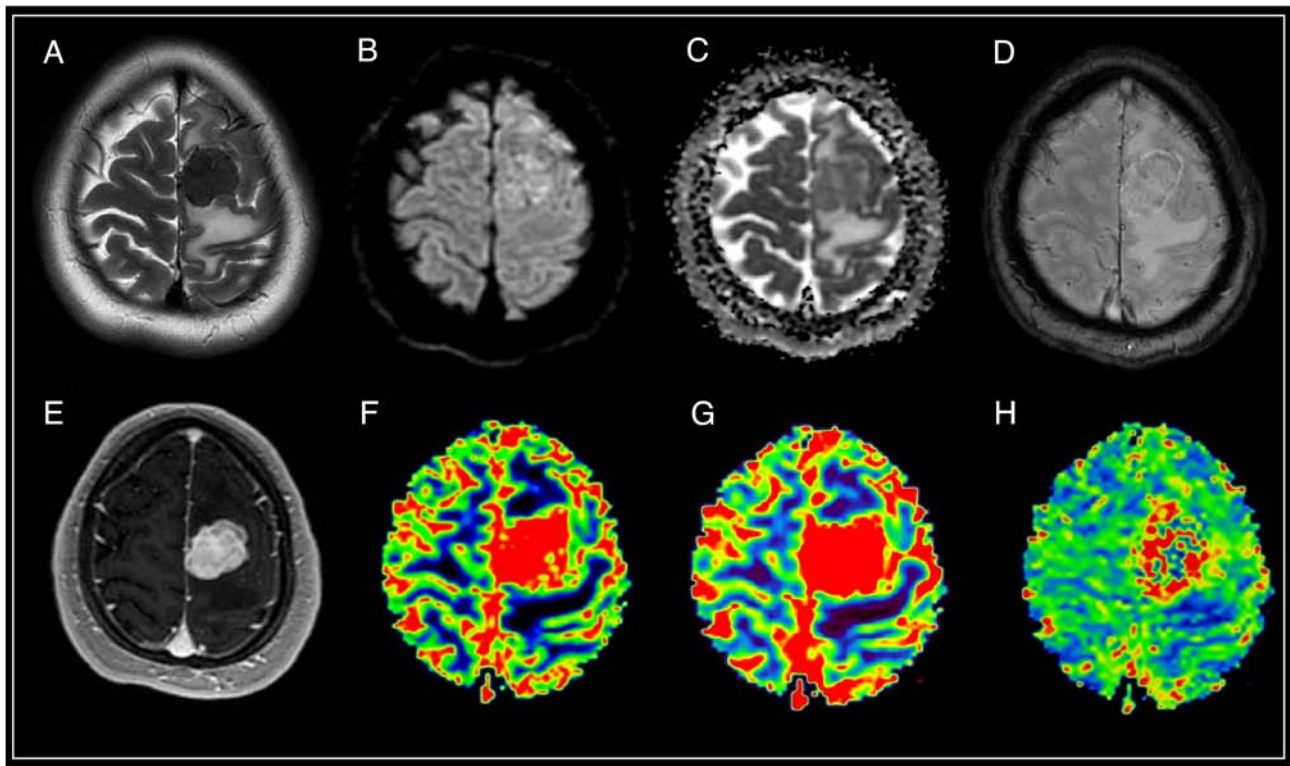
Brain magnetic resonance imaging of a patient with meningothelial meningioma (WHO Grade 1). Supratentorially, in the left hemisphere of the frontal region, against the background of moderate vasogenic edema, a clearly demarcated extracerebral mass is visible, characterized by a hypointense signal on T2-WI, intense and homogeneous accumulation of a contrast agent, diffusion restriction with corresponding areas of increased values of volumetric and velocity cerebral blood flow, as well as prolongation of blood transit time. SWAN indicates the presence of cortical draining veins in the formation structure. (A) T2-WI; (B and C) DWI and ADC; (D) SWAN; (E) T1-WI with contrast; (F) CBV; (G) CBF; and (H) MTT. SWAN, susceptibility-weighted angiography; T1-WI, T1-weighted image; T2-WI, T2-weighted image; DWI, diffusion-weighted imaging; ADC, apparent diffusion coefficient; CBV, cerebral blood volume; CBF, cerebral blood flow; MTT, mean transit time.
